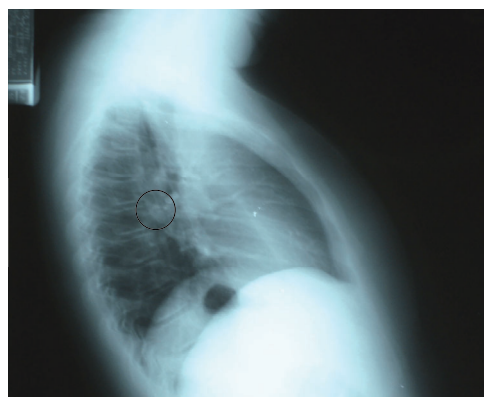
Lateral chest X-ray showing location of tooth (circled)
